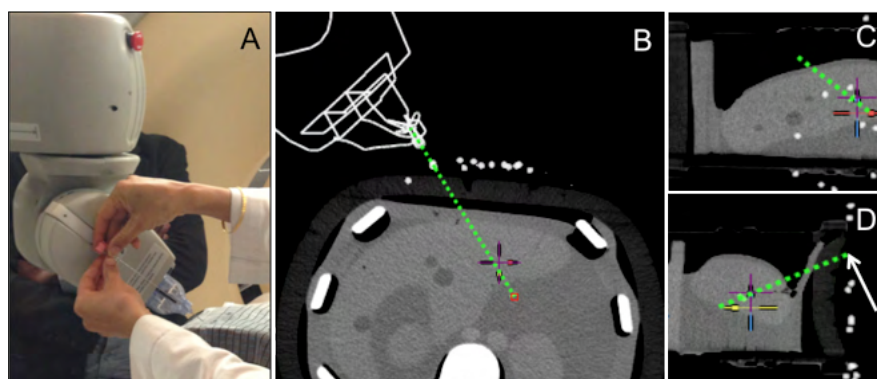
Physician inserts the needle through needle guide at the end effector of the robotic arm (1A). Graphical user interface of IR assistance platform provides multiplanar display of planned needle trajectory (1B-D). The point target is delineated by a red square on axial CT (1B). Skin-entry point (solid arrow), though out of plane in the axial (1B) and coronal view (1C), is delineated in the sagittal plane (white arrow) (1D).
